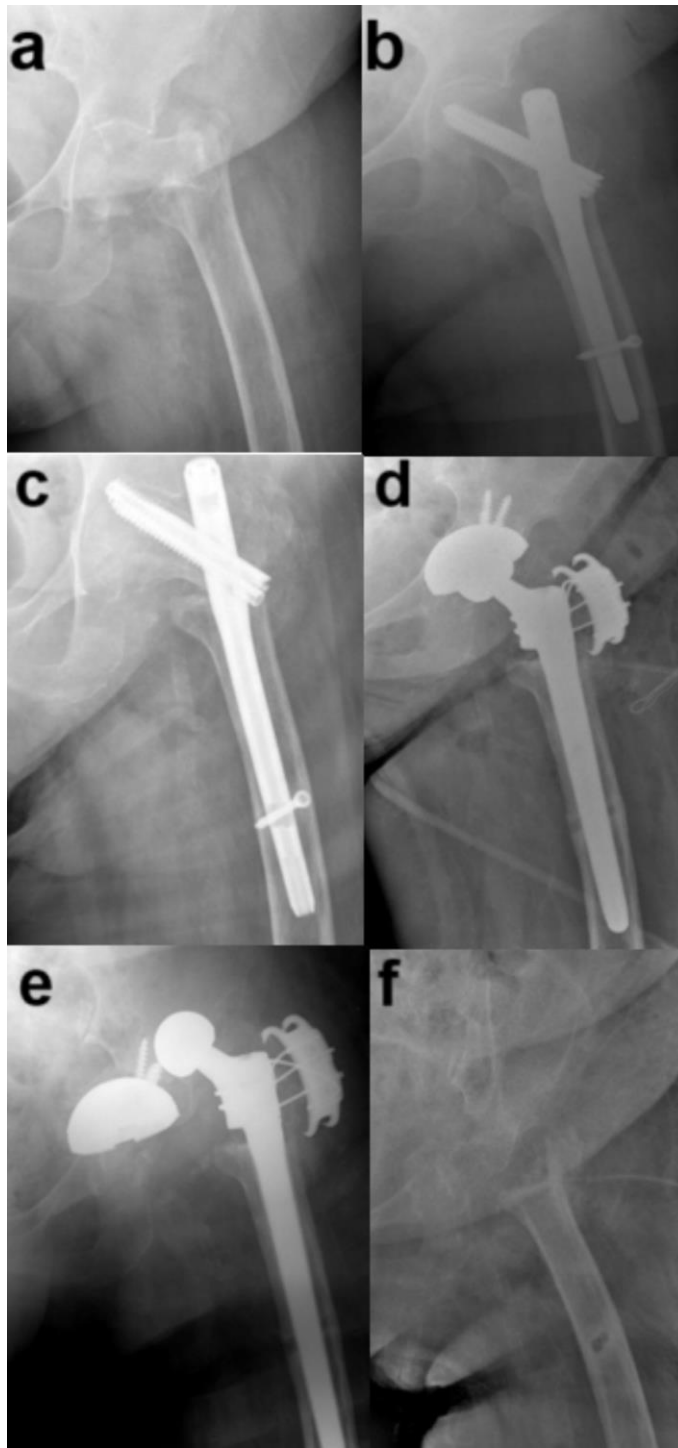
a) Appearance of AO/OTA type 31-A1.2 fracture on the left hip radiograph of a 90-year-old female patient. b) Early radiographic appearance of the hip after fixation with proximal femoral nail (PFN). c) In the patient's 7-month follow-up radiograph, it was determined that the lag screw was cut-out superiorly. d) Radiographic appearance of the patient after removal of the PFN implant and total hip arthroplasty (THA). e) Appearance of the patient's left hip dislocated and the acetabular cup migrated to the pelvis at 1 month after THA. f) Finally, all components of the patient's hip were removed and the Girdlestone procedure was performed.
